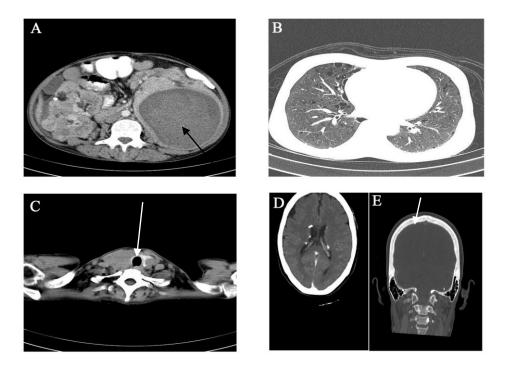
(A) CECT Abdomen shows Angiomyolipoma in kidney (B) HRCT Thorax shows
